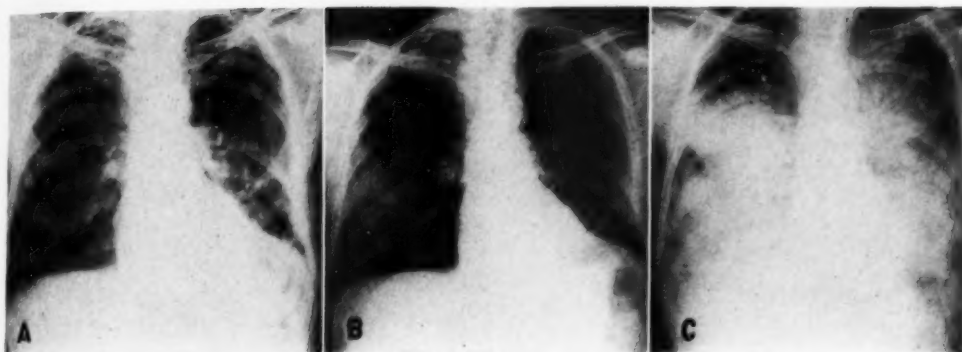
Case II. Serial roentgenograms after left lower lobectomy demonstrate the progression of the disease. A. Two months after lobectomy there is beginning nodular change in the lower right lung. The haziness in the left is largely a post-surgical residual. B. Five weeks later, the disease has advanced considerably on the right, causing homogeneous nodular and patchy densities. C. Four months later. There now is widespread involvement on both sides, leaving very little aerated lung. Note the similarity in the type of density to that shown in Case I.
